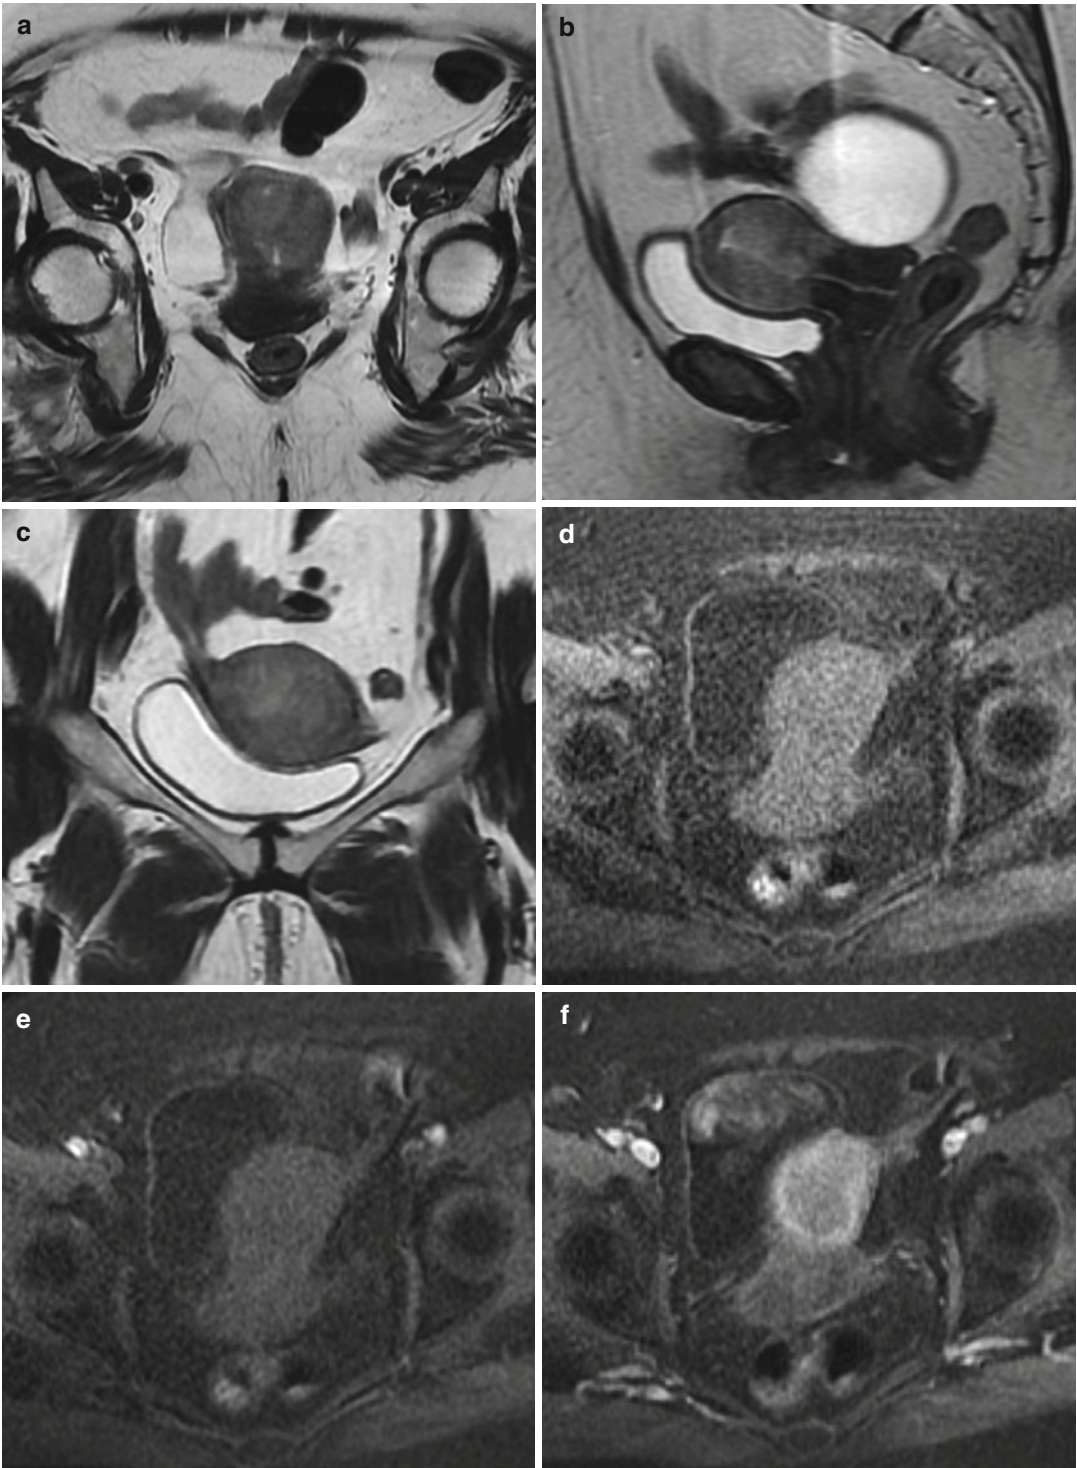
Endometrioid adenocarcinoma of the endometrium in a 80-year-old female. T2-weighted transverse (a), sagittal (b), and coronal (c) demonstrate abnormal intermediate signal intensity affecting the uterine corpus, in keeping with a diffuse infiltrative tumor. Transverse
